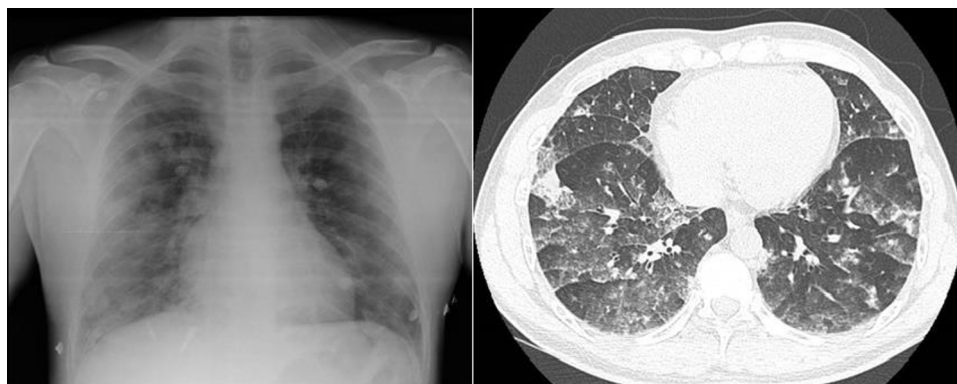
On the left, chest X-ray with bilateral reticular cotton-wool infiltrates. On the right, CT-angiogram (parenchymal window) showing alveolar and ground glass opacities in both lungs.
